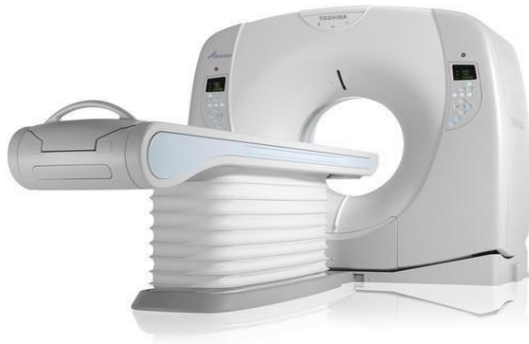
Toshiba Prime Aquilion 160 slice CT
